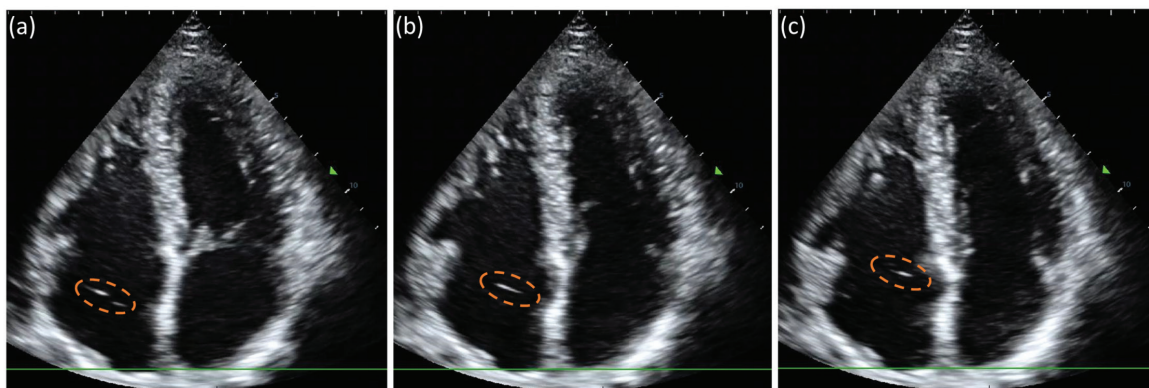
Example echocardiogram of diver showing VGE (circled in orange) in the venous chambers where the valves are open. These are three consecutive frames from the same recording (30 frames per second recording frame rate), showing the two bubbles visible on (a), superimposed in (b), and appearing as a single bright spot in (c) where one might have moved out of plane.
